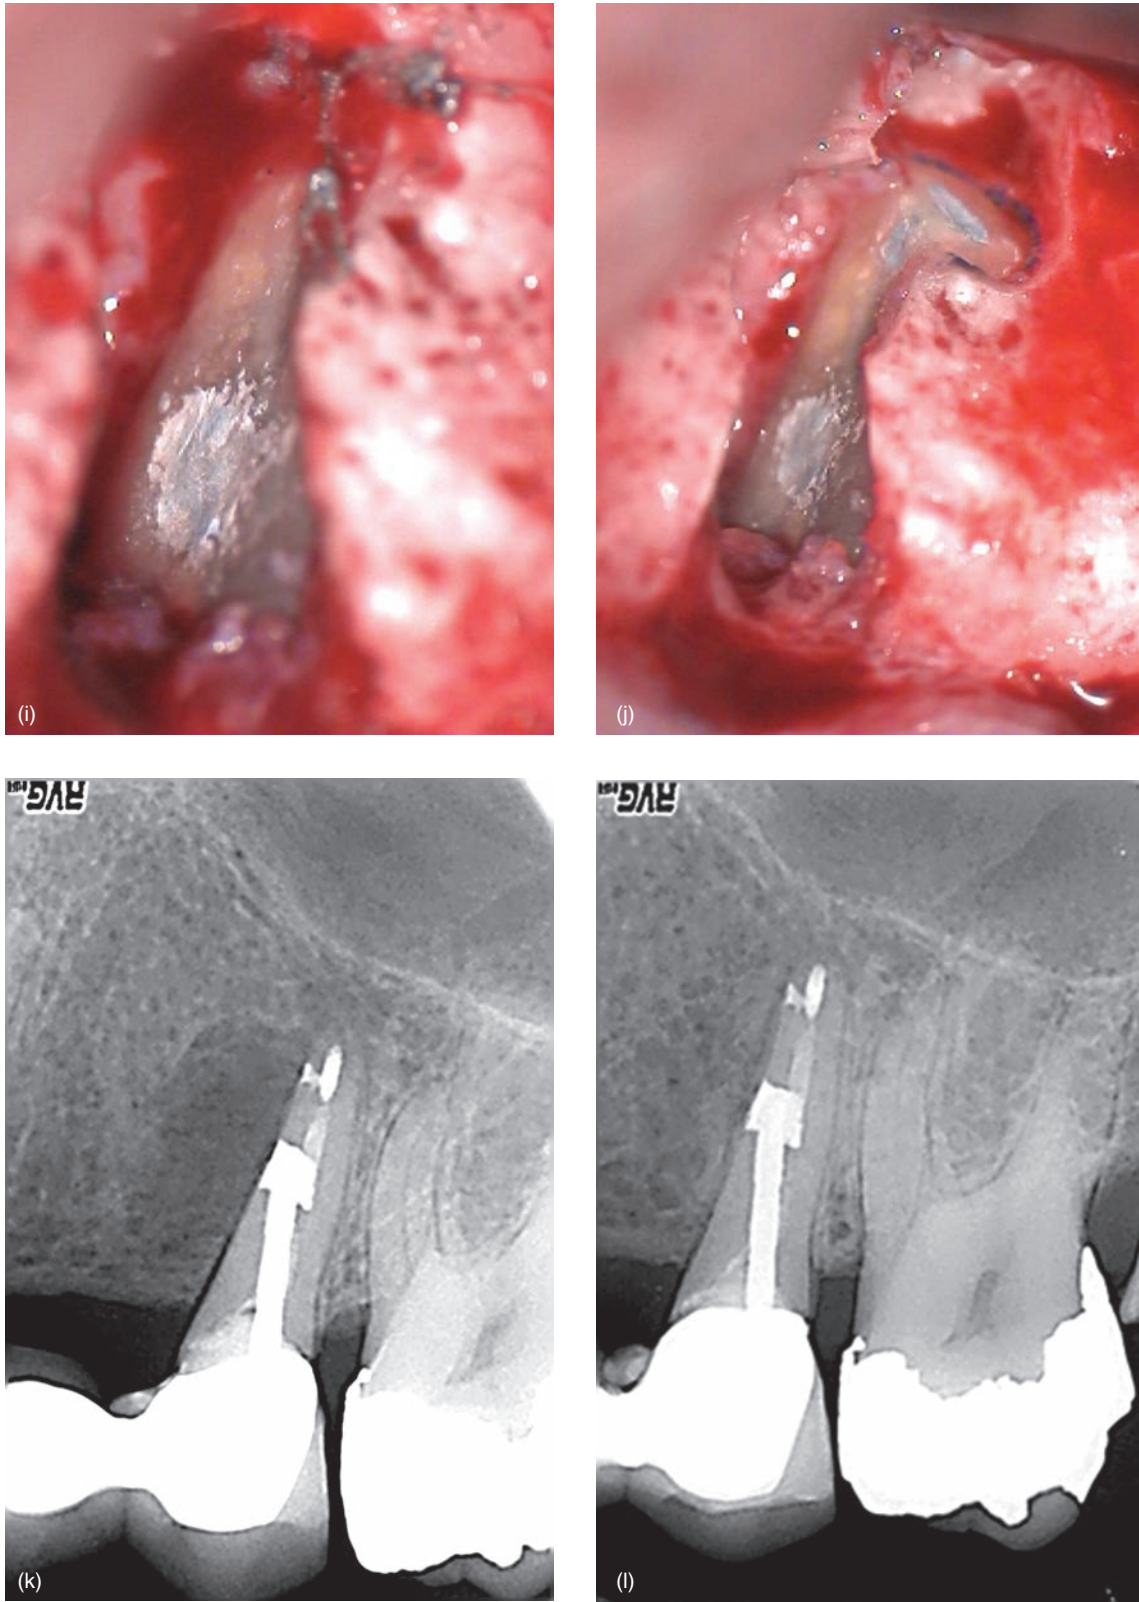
(Continued) (i) Perforation site repaired with SuperEBA; (j) surgical site and retrofills of the perforation, root apex, and a mesial lateral canal at the apical level (note that the root was not cut below the mesial lateral canal apically to preserve a longer root length for better retention of the three-unit bridge); (k) postoperative radiograph; (l) 6 month follow-up radiograph shows evidence of complete osseous regeneration.
